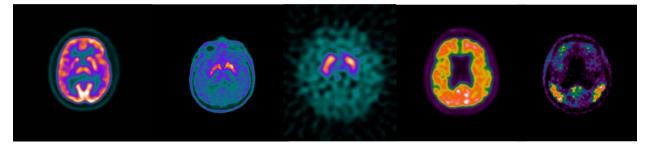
Representative images of the most used molecular imaging techniques targeting the pathological substrates of neurodegeneration; from the left to the right: glucose consumption (PET with glucose analog [18F]FDG); presynaptic dopamine transporters function (SPECT with [123I]ioflupane also known as DaTscan); nigro-striate synthesis of dopamine (PET with [18F]DOPA); β-amyloid deposition (PET with [18F]flutemetamol); tau protein accumulation (PET with [18F]GTP1)
